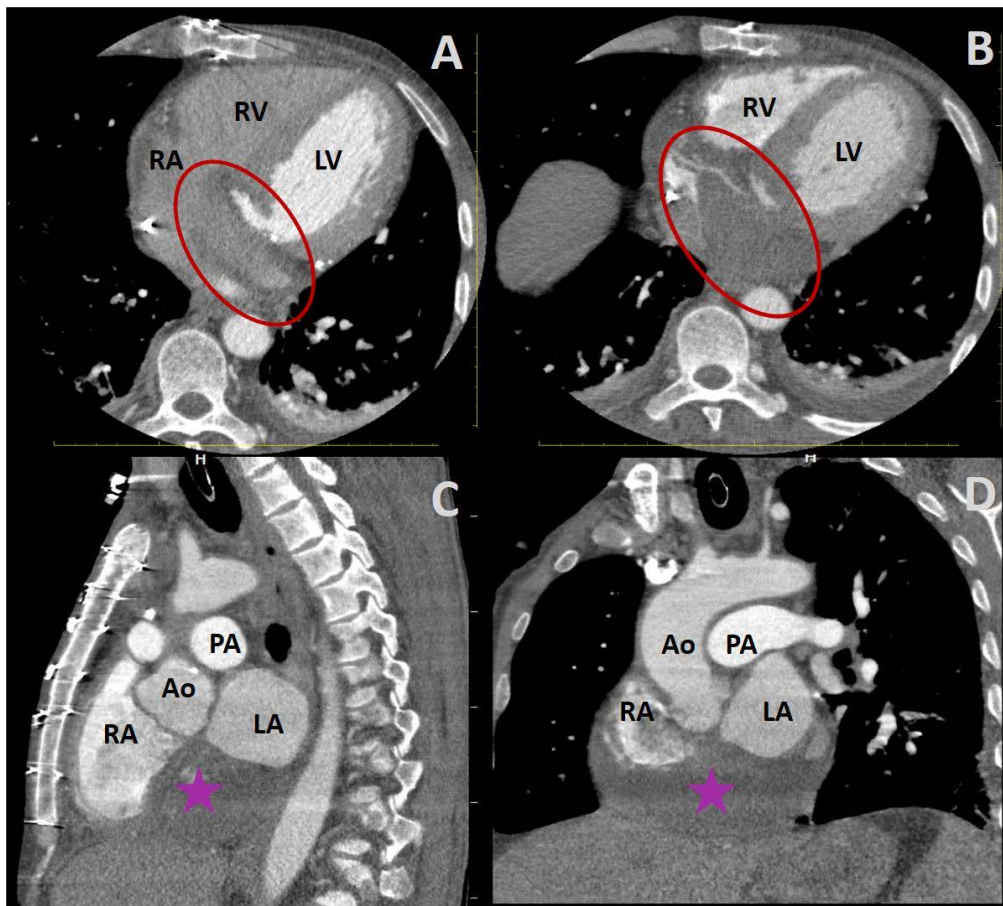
Cardiac computed tomography imaging. A–B) Axial, C) sagittal, and D) coronal views demonstrating a coronary sinus filled with an abscess (red-yellow circles and purple-red stars)
